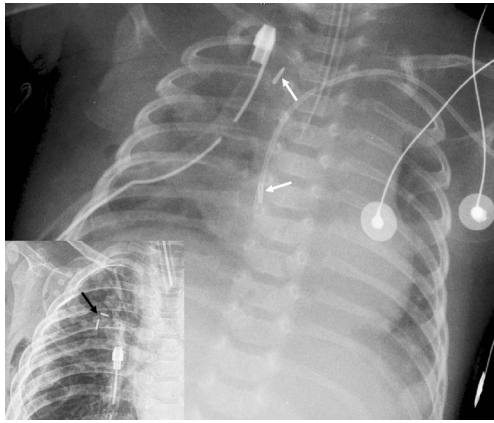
Chest radiographs of the Foker external traction procedure for long-gap esophageal atresia. Immediately after the initial operation, the tips of the upper and lower esophageal pouches are marked by clips (large image, *white arrows*). Daily increasing traction is applied, until the tips approximate 5 days later (left lower inset, *black arrow*), indicating that a low-tension anastomosis can be performed
